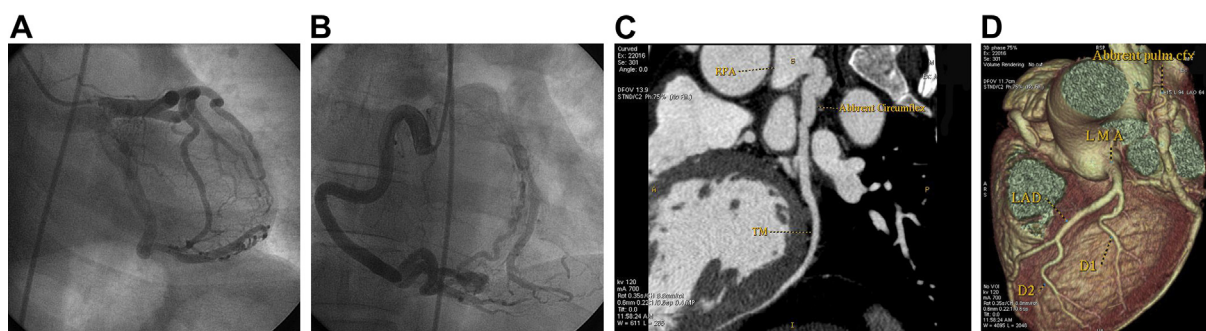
Anomalous origin of left circumflex artery from pulmonary artery. (A) Left coronary angiogram (RAO projection) showing LCX (arrow) filling through collaterals from LAD and draining into MPA. (B) Right coronary angiogram (AP projection) showing LCX (arrow) filling through collaterals from RCA and draining into MPA. (C) CT angiogram showing anomalous origin of LCX from RPA. (D) CT reconstruction showing anomalous origin of LCX from RPA. RAO – Right Anterior Oblique; LCX – Left Circumflex; RCA – Right Coronary Artery; AP – Antero Posterior; RPA – Right Pulmonary Artery; MPA – Main Pulmonary Artery.
